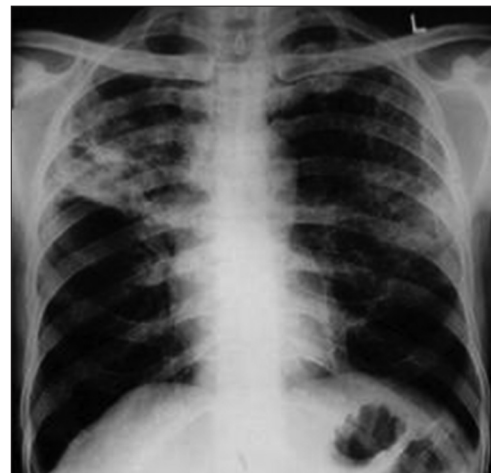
Chest radiography revealing bilateral upper-lobe infiltrates suggestive of tuberculosis
